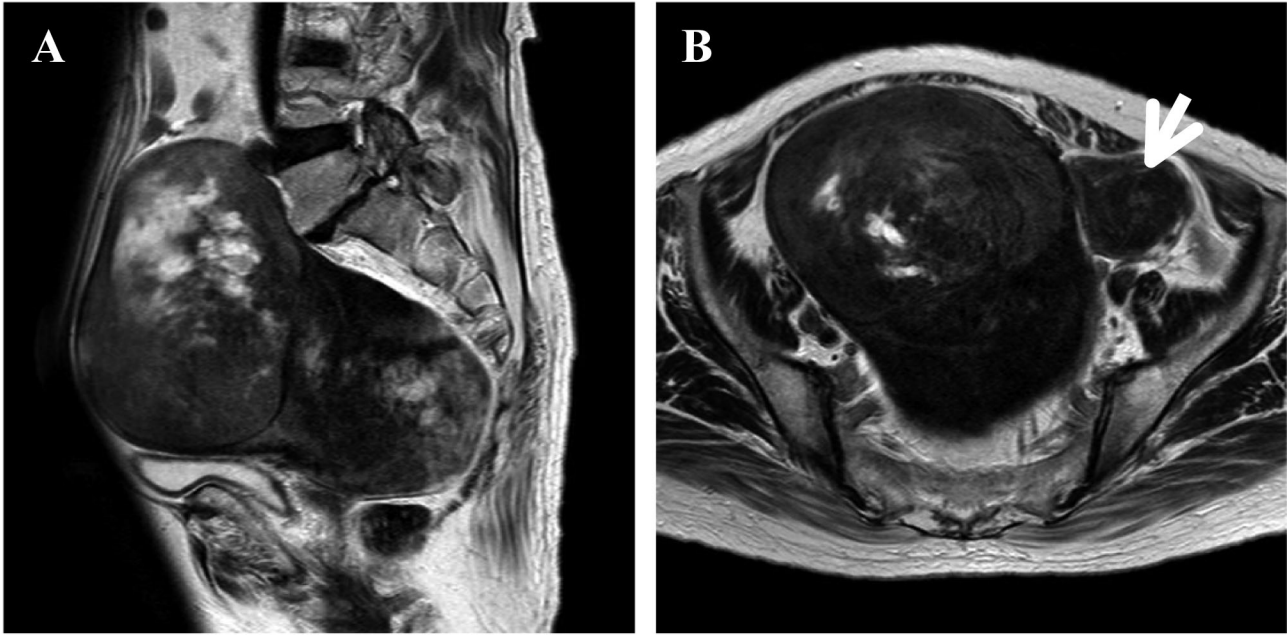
Saggital (a) and axial (b) T2-weighted MR images showing a huge pelvic heterogenous mass associated with little enlarged uterus (arrow).
